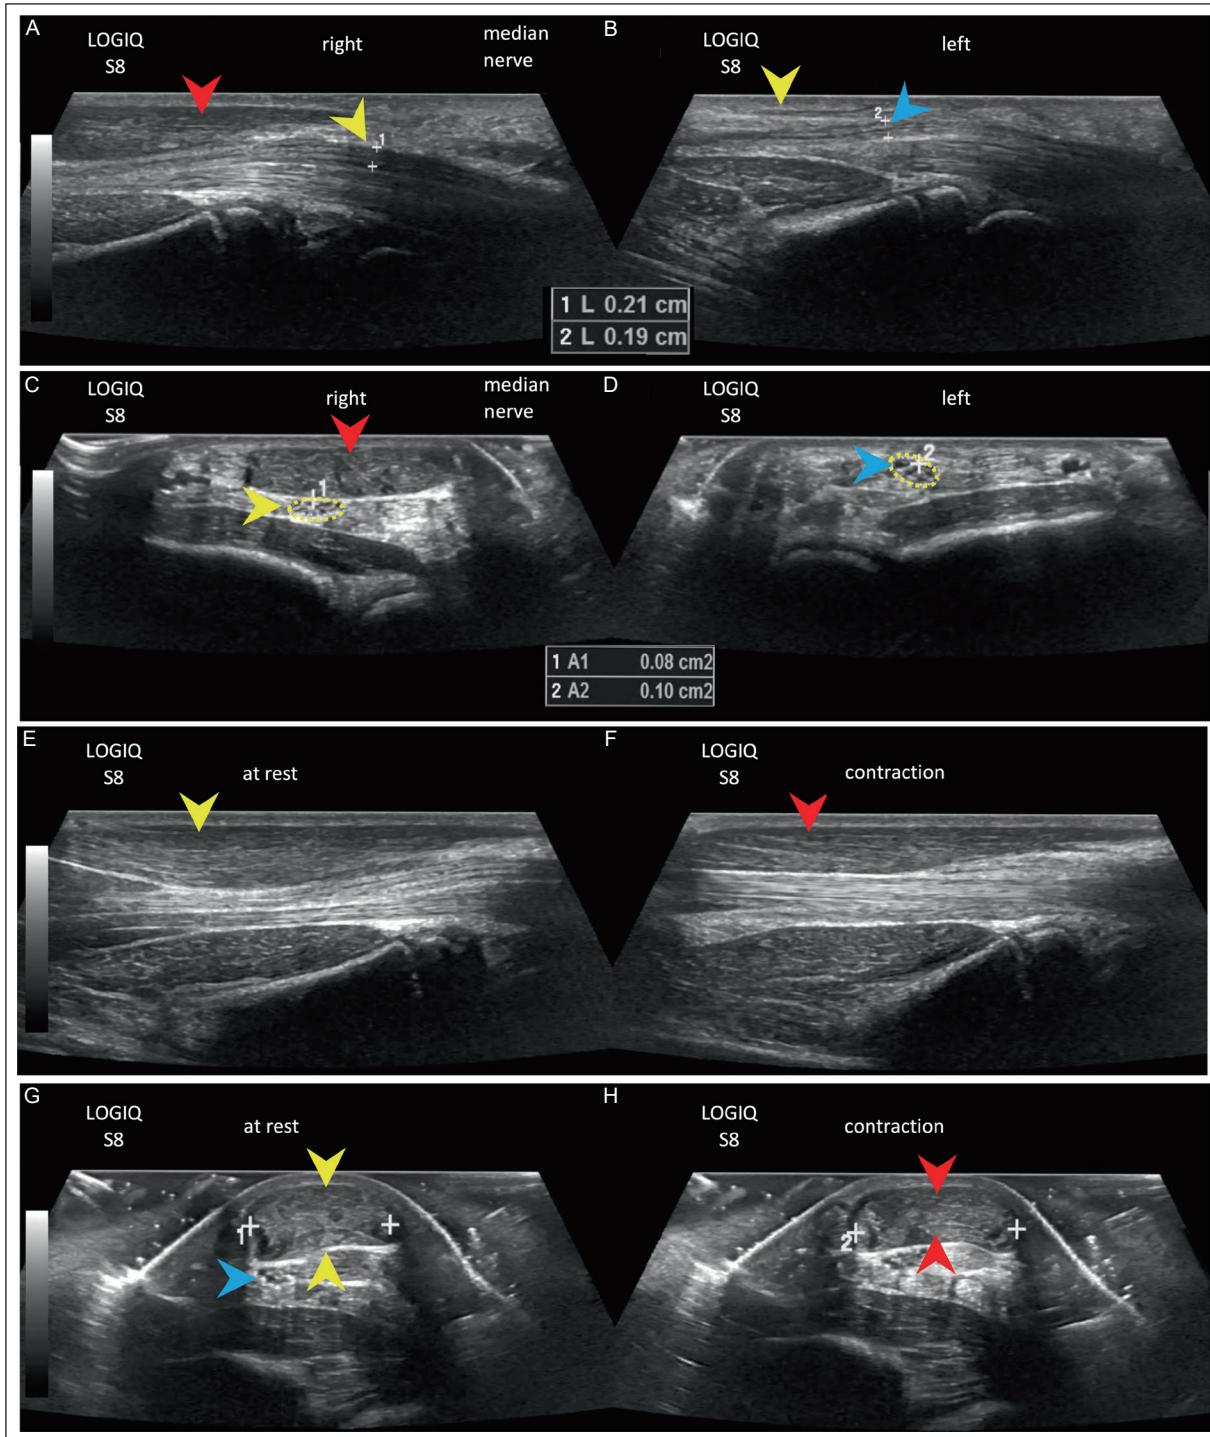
A 13-year-old boy with a painful palpable mass in the right distal forearm diagnosed with RPLM. A: grayscale MSK-US longitudinal shows the right-sided RPLM (red arrowhead) extending toward the carpal line over the MN (yellow arrowhead). The MN has an increased anteroposterior diameter of 0.21 cm. B: contralateral, left forearm, shows the MN with an anteroposterior diameter of 0.19 cm (blue arrowhead), normal palmaris longus tendon is shown (yellow arrowhead). C: grayscale MSK-US transverse of the middle third of the right RPLM (red arrowhead) compressing the MN (dotted circle). The cross-sectional area is 0.08 cm² (dotted line). D: grayscale transverse MSK-US of the left MN with an area of 0.10 cm² (dotted circle). E: grayscale longitudinal MSK-US of the RPLM at rest, showing muscle thickness (yellow arrowhead). F: grayscale longitudinal MSK-US of the RPLM during eccentric contraction, showing reduced muscle thickness (red arrowhead). G: grayscale transverse MSK-US of the RPLM at rest showing muscle thickness (yellow arrowheads) and MN compression (blue arrowhead). H: grayscale transverse MSK-US of the RPLM during eccentric contraction, confirming decreased muscle thickness (red arrowheads). RPLM: reversed palmaris longus muscle; MN: median nerve; MSK-US: musculoskeletal ultrasound.
